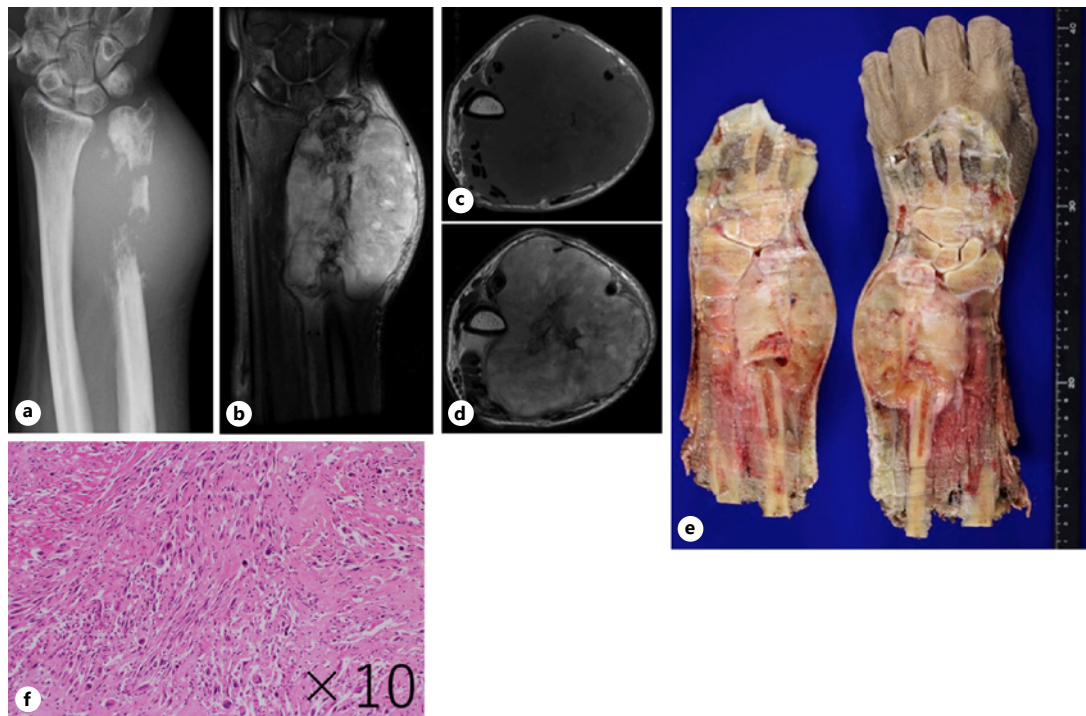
a–d Radiographs and MRI after 2 cycles of neoadjuvant chemotherapy with ifosfamide and pirarubicin. a Radiograph showed rapid growth of the tumor and severe bony destruction of the ulna. b–d MRI showed marked enlargement of the tumor and infiltration of the neurovascular bundle. e Postoperative gross findings showed a yellow-white solid tumor approximately 8 cm in size with no obvious involvement of the carpal bones or the radius. f Postoperative pathology showed spindle cell proliferation in a fascicular pattern with marked nuclear atypia, mitosis, and osteoid formation.
